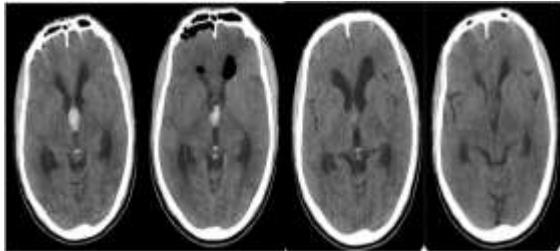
Serial CT scans showing incomplete aspiration of cyst which resolved over time
